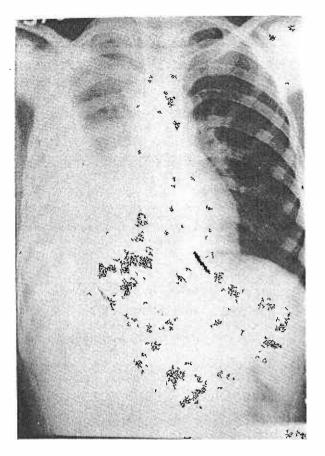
Radiograph of the chest to show a pleural effusion before therapy.
